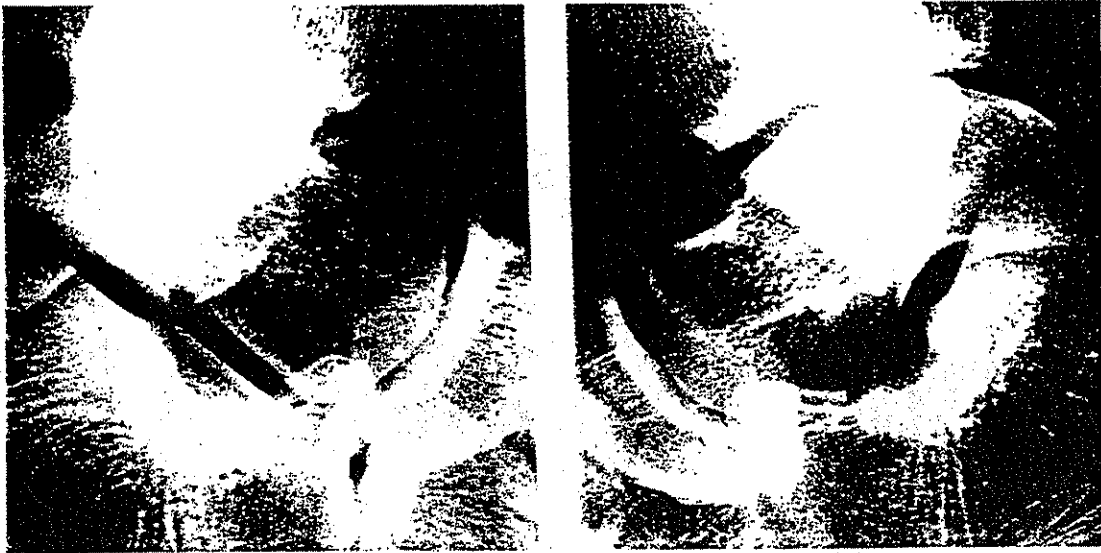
Lateral roentgenogram of the ankle and subtalar joints of a normal (left) and clubfoot (right). Note the smaller size of the articular facets of the subtalar joint in the clubfoot.
